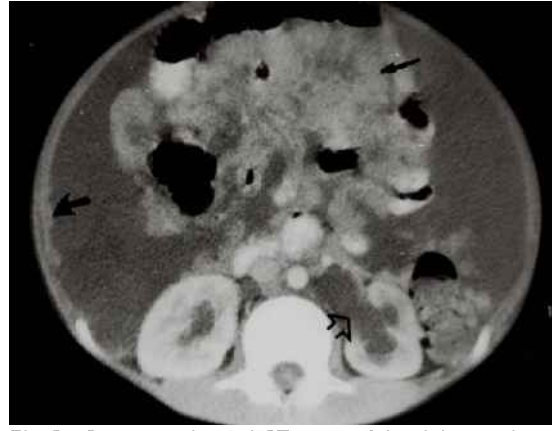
Contrast-enhanced CT image of the abdomen shows multiple soft tissue mass lesions in the mesentery (arrow), ascites, nodular thickening of parietal peritoneum (curved arrow) and left-sided hydronephrosis (open arrow).
